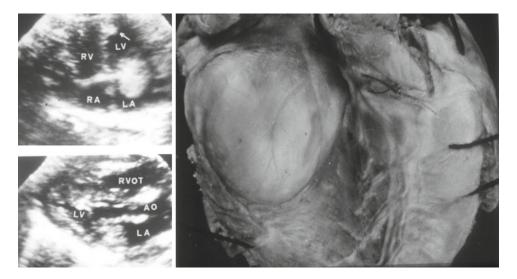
Neonatal echocardiography. Reprinted with permission of the Italian Society of Cardiology. Two rhabdomyomas, the smaller at the apical segment of the interventricular septum (*arrow*) and the larger in the left
